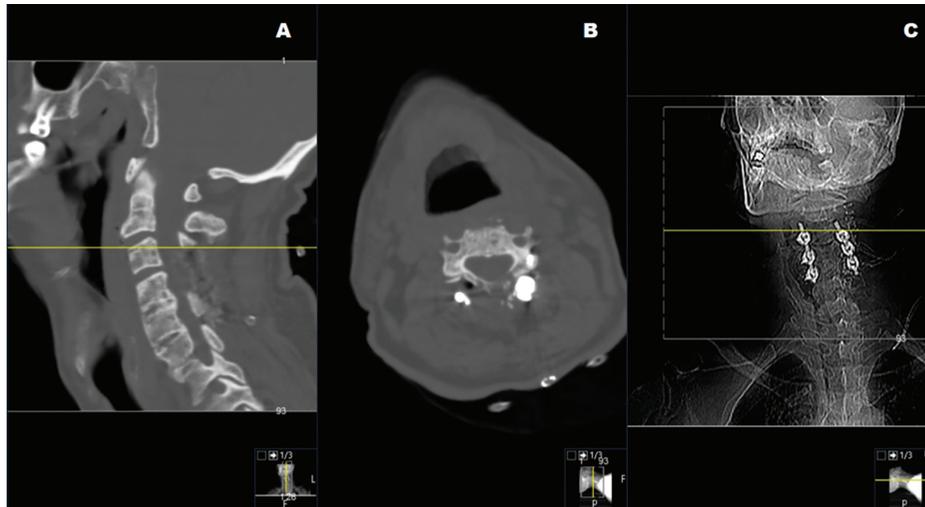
Preoperative CT images, (A) sagittal reconstruction, (B) axial scan, (C) anteroposterior scout view.
